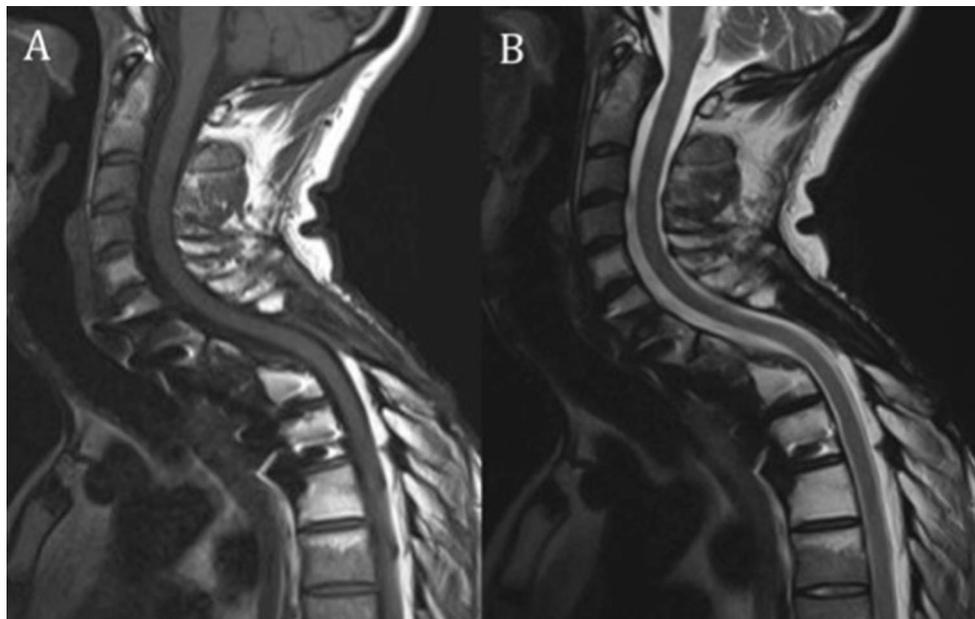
Post-operative sagittal T1 (a) and T2 (b) MRI sequences
